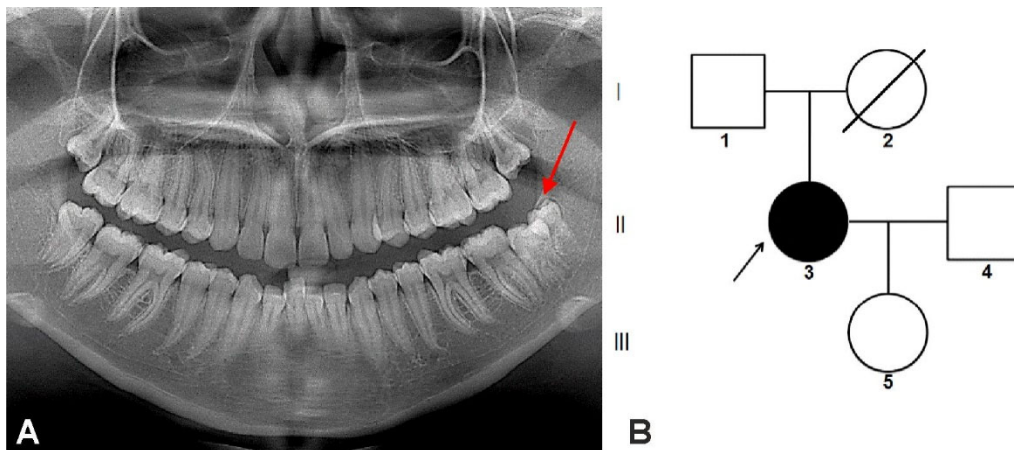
Lower permanent distomolar (3.8 bis) – isolated, sporadic, non-hereditary, nonsyndromic case (32-year-old woman). Panoramic radiograph showing the supernumerary tooth (A); the family tree: isolated, sporadic, non-hereditary case (B).
